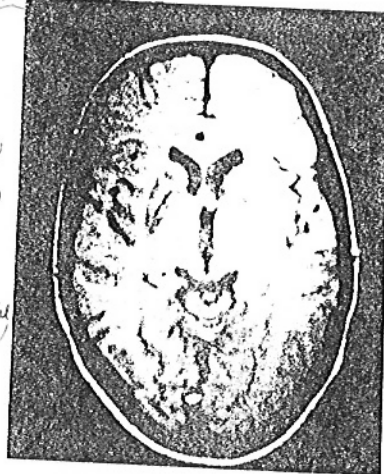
Case 5. Horizontal MRI section (T1 weighted) showing abnormal signals in both pallidal areas.
